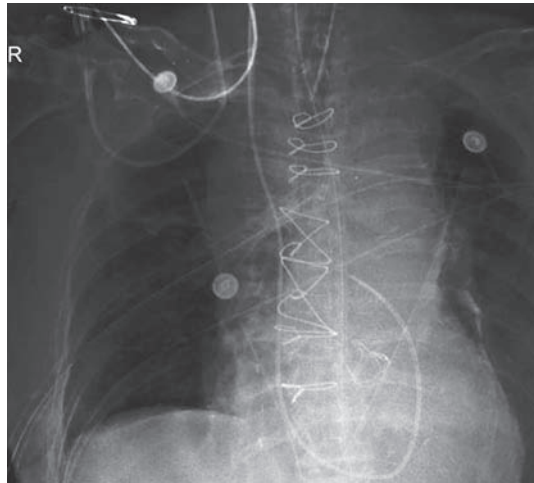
Chest X-ray showing right heart catheter in right pulmonary artery
